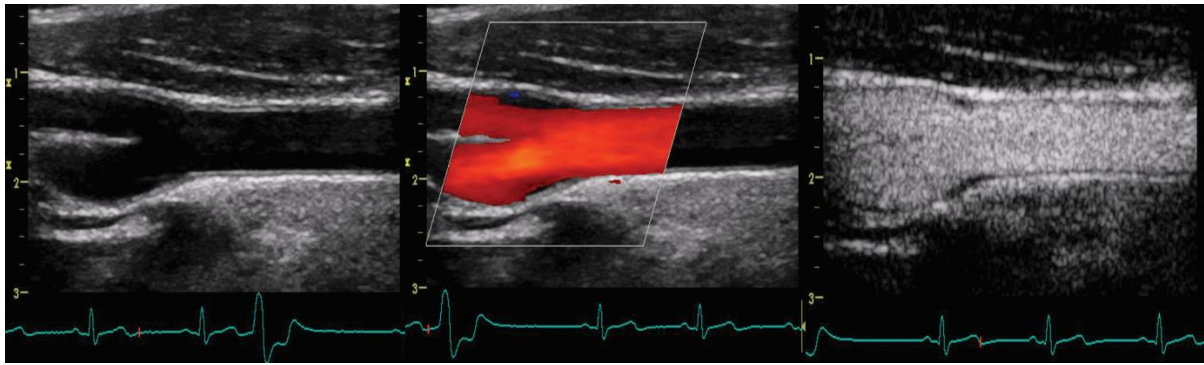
Examples of B-mode (left), colour Doppler (centre) and CEUS (right) imaging of the carotid arterial tree. The figures show a long-axis view of the common carotid artery with bifurcation into internal and external carotid arteries.
